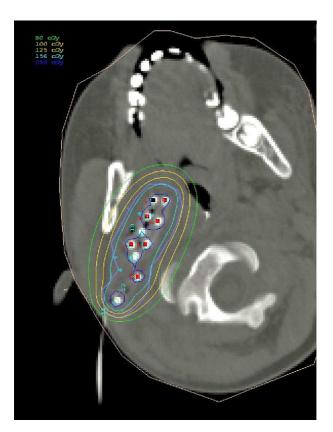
Computed tomography (CT) scan image at brachytherapy treatment planning. The residual tumour mass is removed and the gutta percha moulage is *in situ*. The moulage is loaded with dummies and the dose distribution is calculated. Reference isodose lines (cGy/h) around the moulage are depicted in colour: green line 80 cGy/h, outer yellow line 100 cGy/h, inner yellow line 125 cGy/h, light blue line 156 cGy/h, dark blue lines 250 cGy/h.
